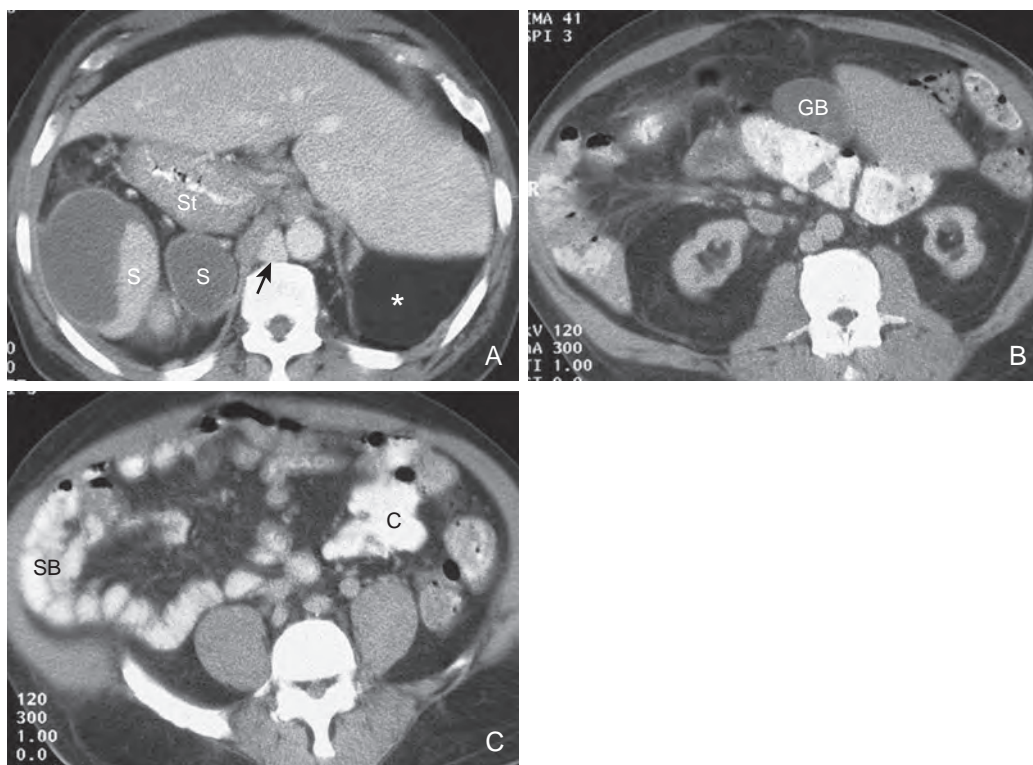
Situs ambiguus with polysplenia in a 67-year-old man. A. Transverse contrast-enhanced CT scan of the abdomen shows a midline liver, multiple spleens (S) in the right upper quadrant adjacent to the collapsed stomach (St), and inferior vena cava interruption with azygos continuation (arrow). The low attenuation of the spleens is related to infarctions, which cause liquefaction and subcapsular hematomas. Notice the absence of splenic tissue in the left upper quadrant (asterisk). B. Transverse CT scan through the midabdomen reveals a midline gallbladder (GB). C. Transverse CT scan through the lower abdomen reveals the small bowel (SB) in the right lower quadrant and the colon in the left lower quadrant. The cecum (C) lies near the midline, a finding that indicates incomplete fixation. (From Fulcher AS, Turner MA: *Abdominal manifestations of situs anomalies in adults*. *RadioGraphics* 22:1439–1456, 2002.)
